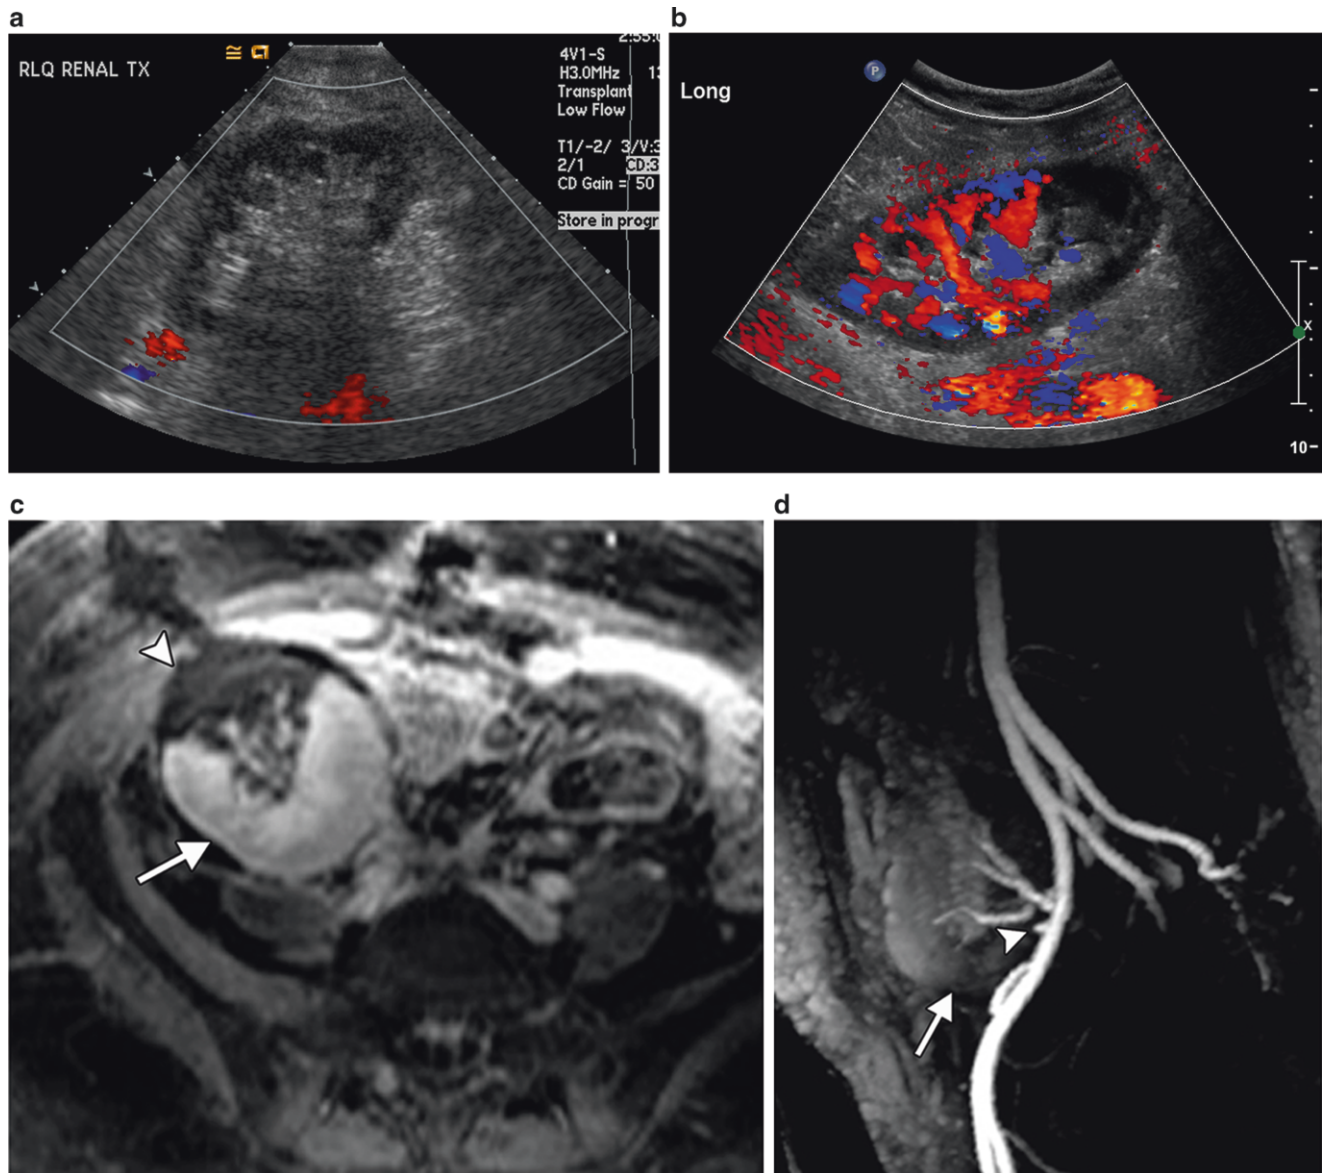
Renal artery thrombosis. (a) Longitudinal color Doppler image shows the absence of color flow throughout the renal transplant. (b) Longitudinal color Doppler image shows segmental lower pole ischemia secondary to thrombosis of one renal artery in a patient with two renal arteries. (c) Fat suppressed, post-contrast T1 weighted MR image shows a
